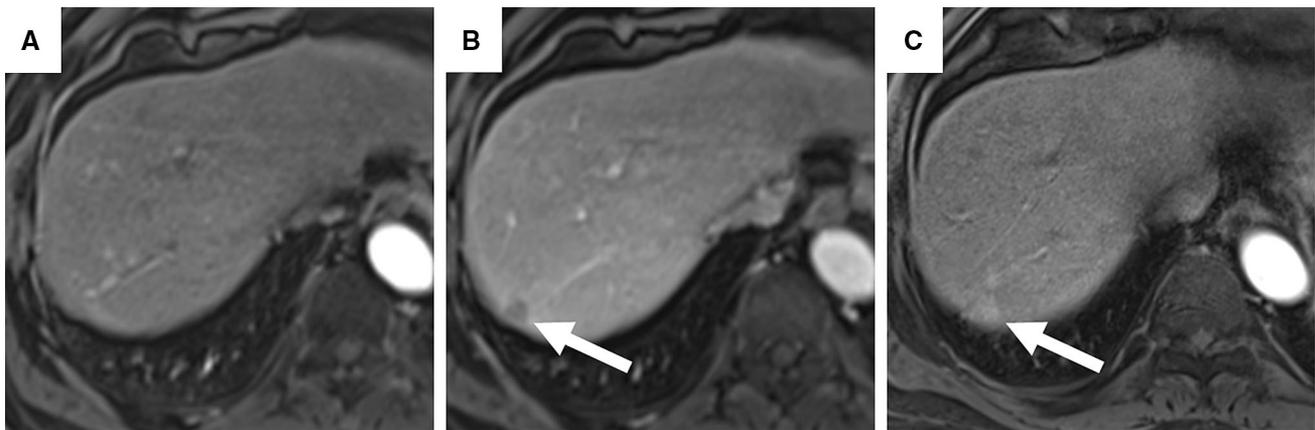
Multiphase MRI performed for this patient with Hepatitis B shows a subcapsular nodule in the hepatic dome (arrowed) that showed no arterial enhancement (A), but did demonstrate a washout appearance (B). Two years
